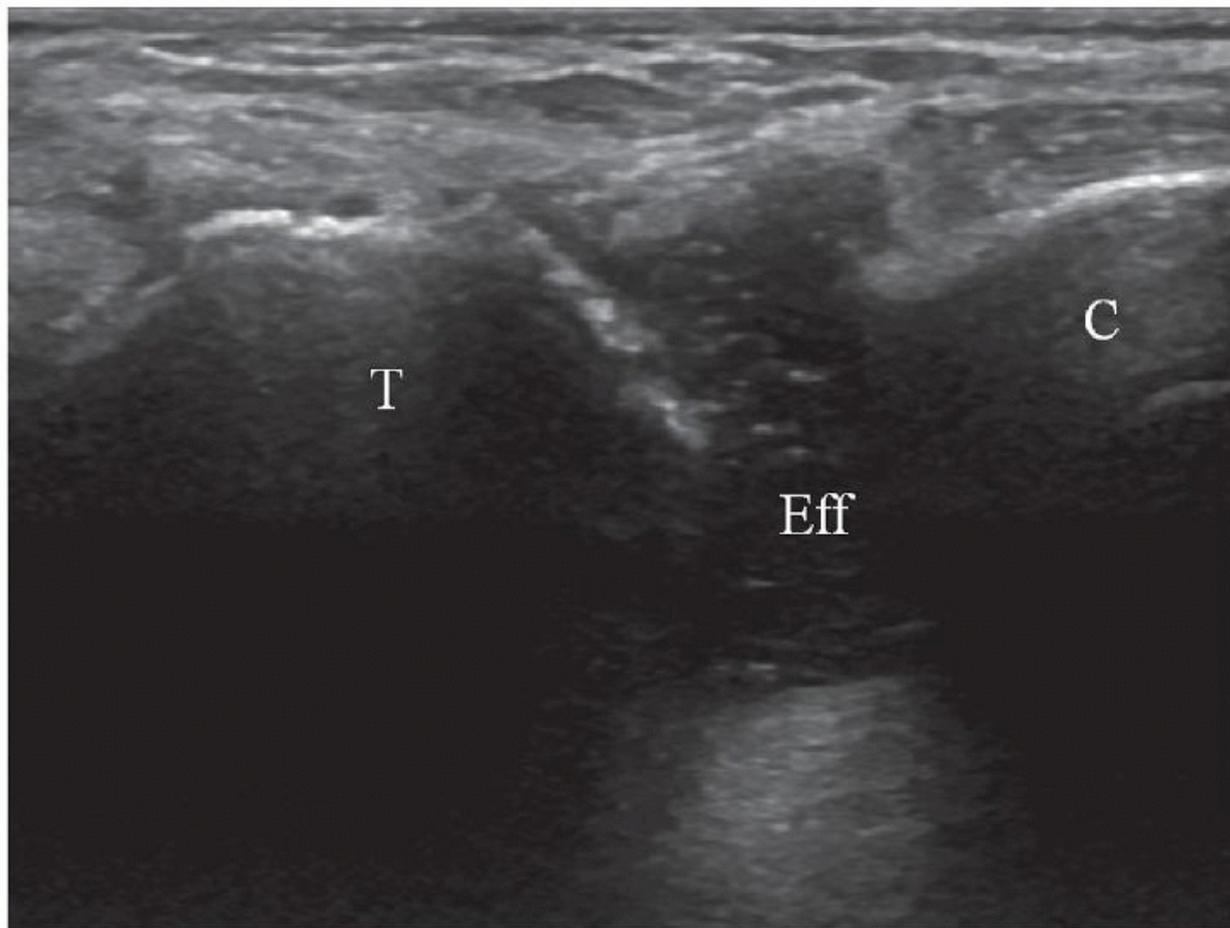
Osteoarthrosis of the posterior talocalcaneal joint. Lateral coronal ultrasound scan showing effusion (Eff) in the anterolateral recess.
